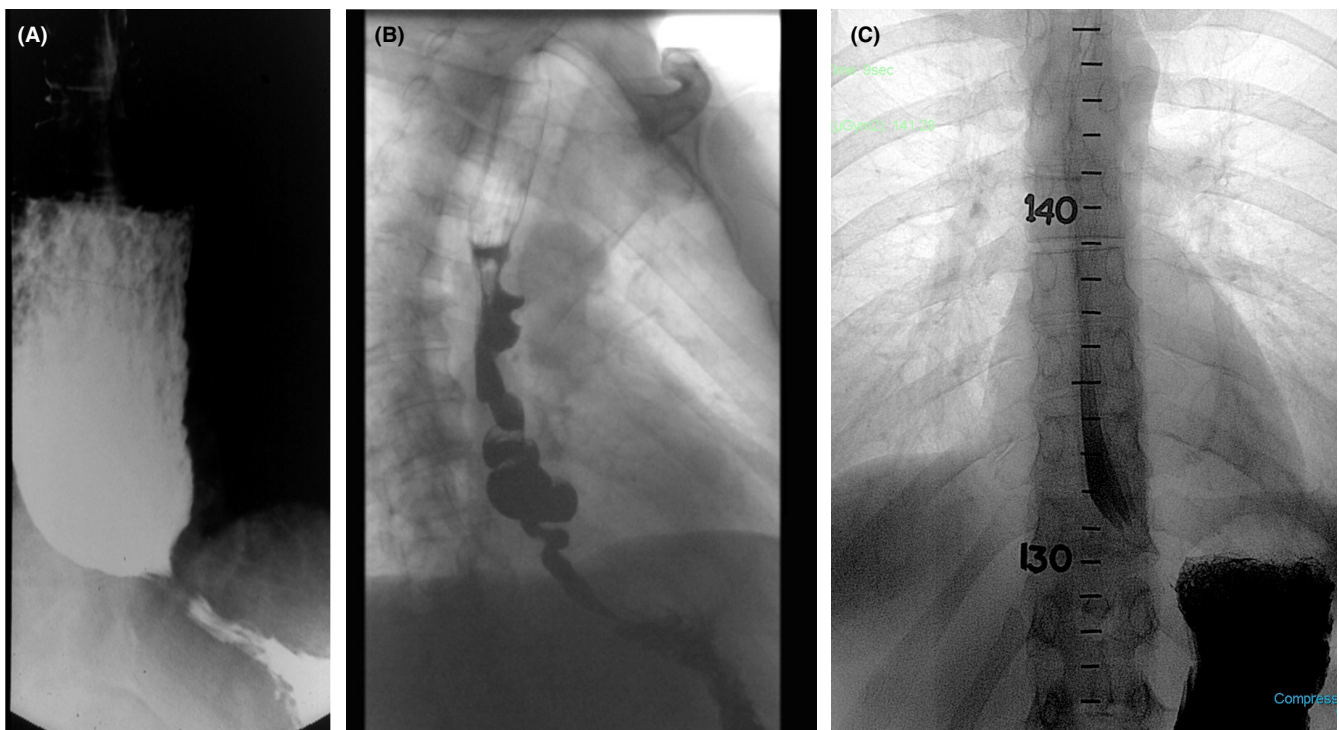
Heterogeneity in radiographic appearance of achalasia. While the dilated esophagus with bird's beak is most characteristic (A), achalasia can equally also manifest with a corkscrew appearance (B) and even a relatively normal, non-dilated esophageal morphology (C).
